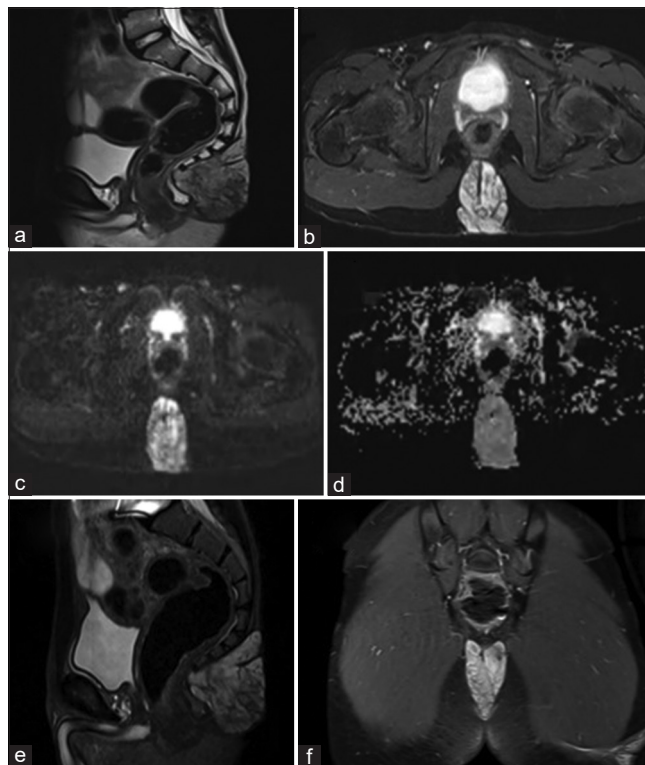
Magnetic resonance images (a-f): Lesion in subcutaneous plane in sacrococcygeal region at upper edge of intergluteal cleft shows intermediate signal on (a) T2W sagittal image, (b) high signal on short tau inversion recovery axial image, with hypointense capsule and septa. Minimal diffusion restriction with low signal on corresponding apparent diffusion coefficient maps (c and d) and intense enhancement with non-enhancing capsule and septa on T1W post-contrast images (e) sagittal and (f) coronal.
